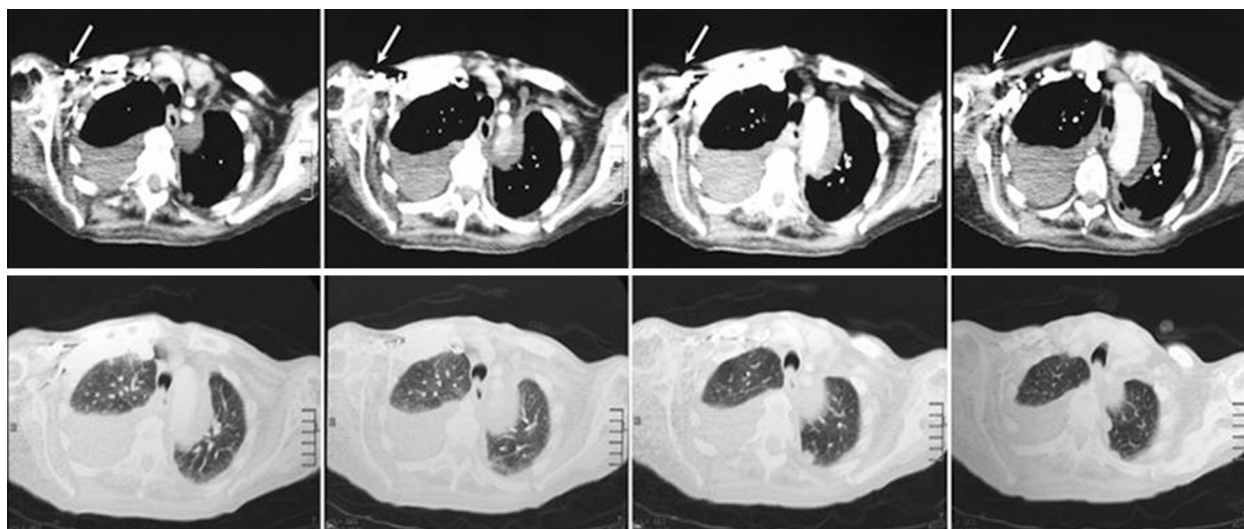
In the thoracic CT sections, bilateral pleural fluid, passive atelectasia in bilateral pulmonary parenchyma, and a mass of approximately 4x5 cm in the right axillary fossa with several nodules in its contiguity (arrow) can be seen, more markedly in the right side.
